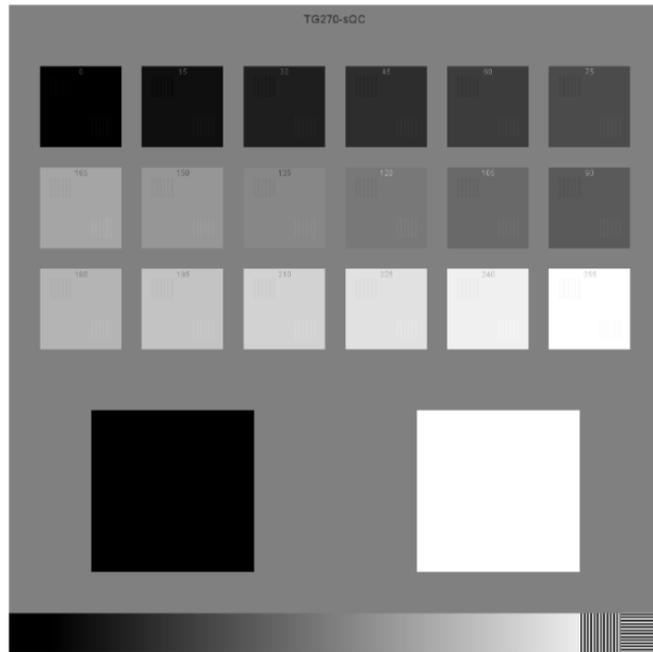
TG270-sQC test pattern for quality control of CT workstation and reporting monitors. From reference 4.
